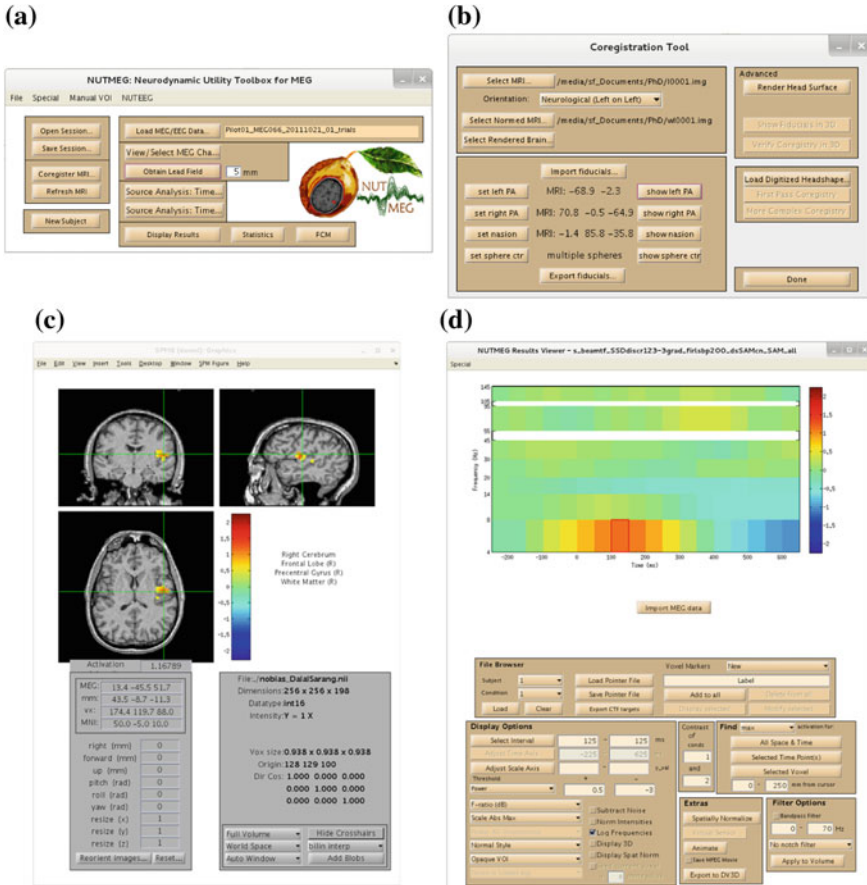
Example components of the NUTMEG graphical user interfaces (GUIs). a The main GUI is designed to guide the user through sequential stages of the data analysis process. b The coregistration interface allows the user to load MRI data along with normalization data and mark the fiducial points. c The SPM8 window allows the user to navigate the MRI, define fiducial points, and visualize activation overlays. d The NUTMEG results viewer showing time-frequency data: the user can specify which frequency band and time point to visualize on the activation overlay in the dynamically linked SPM8 window. The results viewer can also display time-domain data, depending on the type of analysis used
